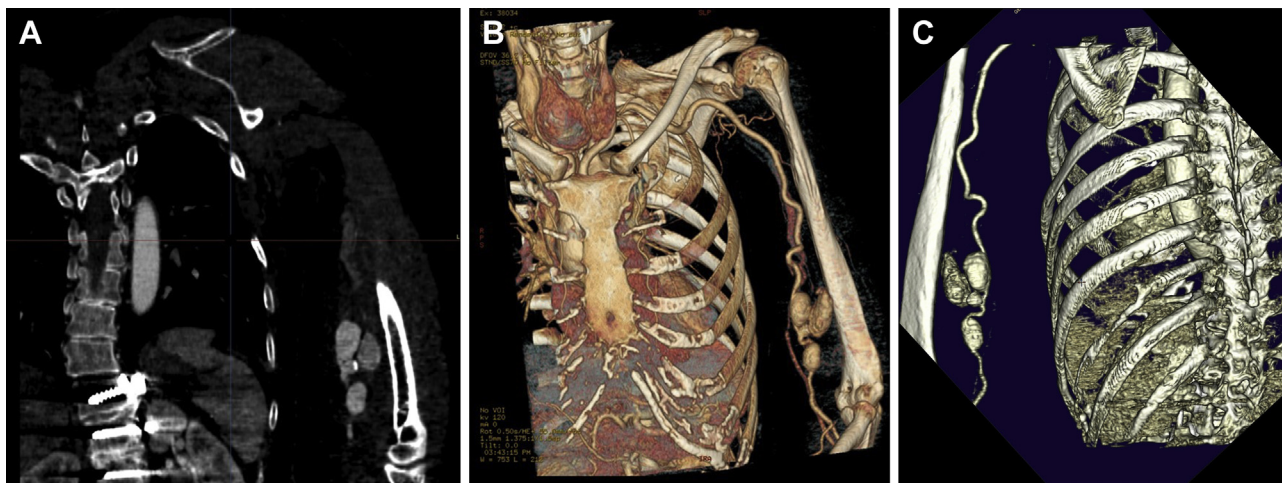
Computed tomography angiography (CTA) and three dimensional images of the three aneurysms. CTA of the left upper arm showed a ruptured aneurysm originating from the brachial artery. Axial (A) view of a ruptured aneurysm with contrast extravasation and soft tissue haematoma. Three dimensional volume rendered images of three aneurysms of which the middle, small aneurysm is ruptured. (B) Anterior view. (C) Posterior view.
